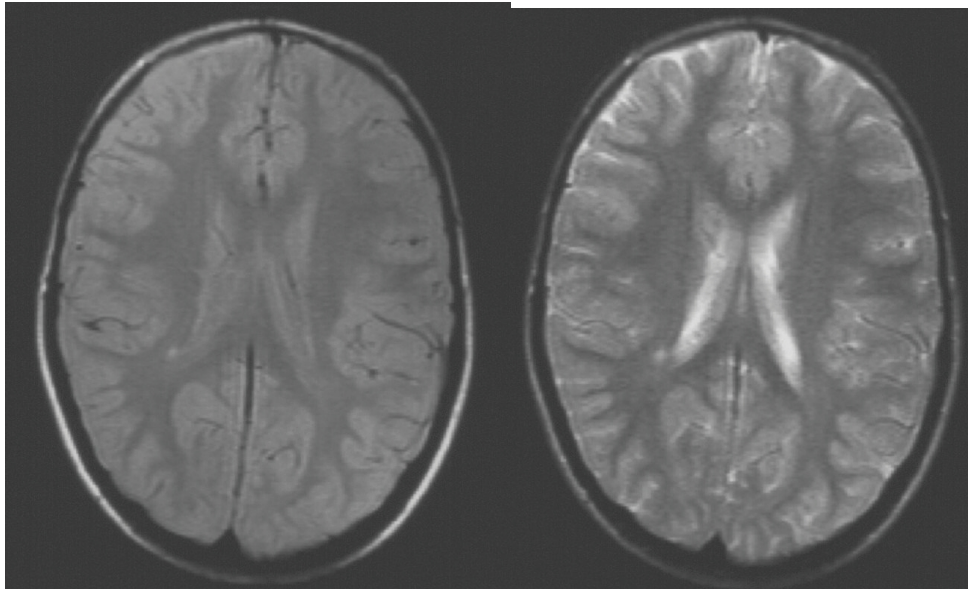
cMRI of proband T.H. Note the hyperintensity located subependymal on the lateral side right of the trigonum. T1-weighted image on left, T2-weighted image on right side.
